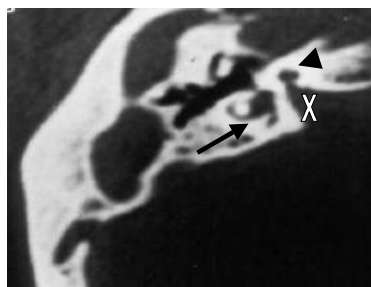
Patient A: CT scan of the right ear in the axial plane. Widened IAC ("X") and hypoplastic cochlea (arrowhead). The vestibule is widened, the lateral SCC is slightly too small (arrow).
